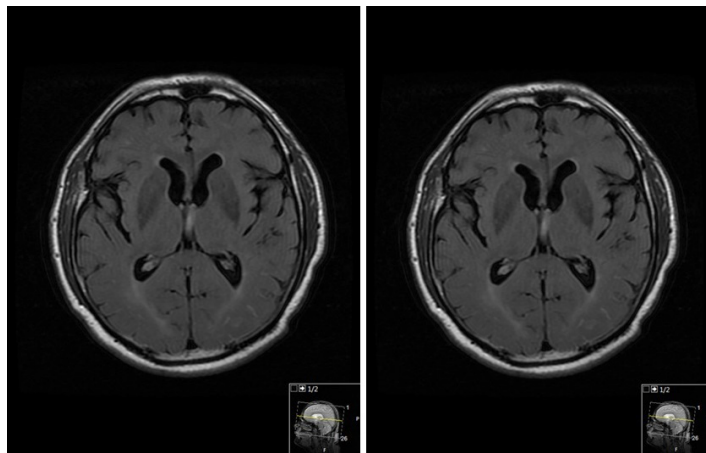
MRI brain FLAIR - nonspecific white matter T2 hyper intensity, most commonly seen with chronic small vessel disease but can be seen with sarcoid.
